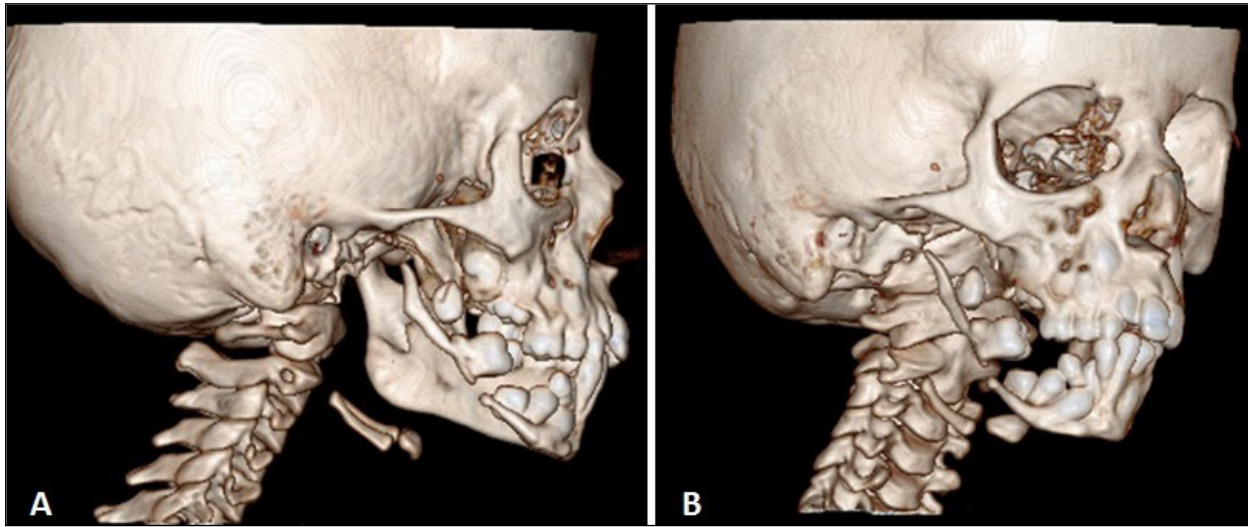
Nine-months post radiation therapy CT scan images showing no further of bone resorption as compared to the previous CT scan images.
